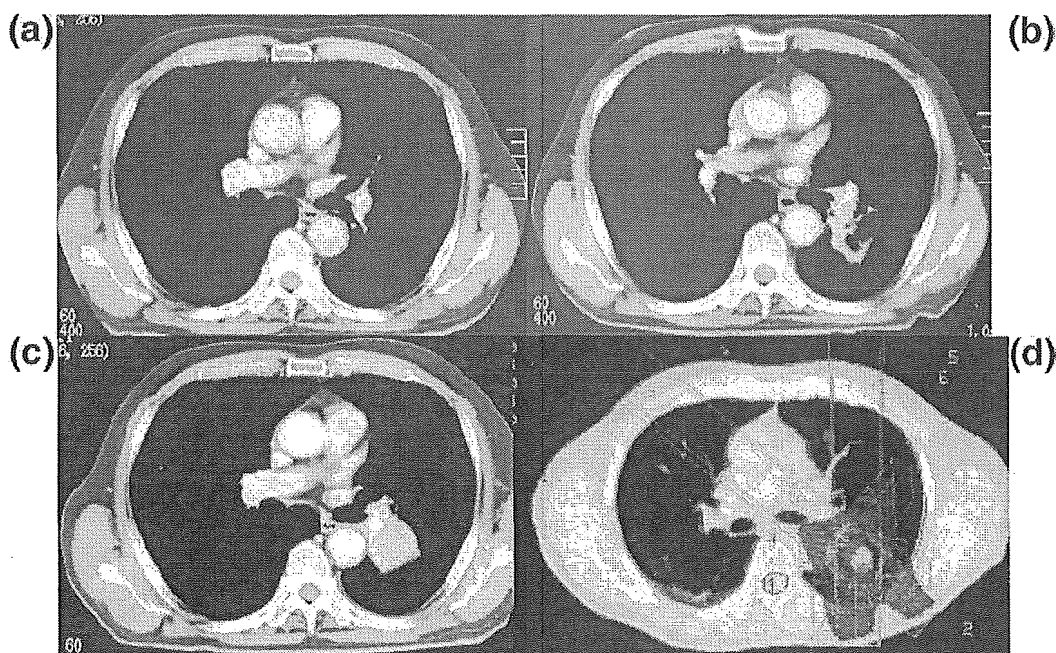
A case of T1N0M0 lung cancer showing recurrence after stereotactic radiotherapy (SRT). The computed tomography images at 7 months (b, upper right) after SRT demonstrated a new soft-tissue density as well as radiation-induced lung damage (RILD) in the marginal area of the SRT that could not be observed at 2 months (a, upper left) after SRT. Initially, the density was considered to be RILD. However, the density increased in size at 16 months (c, lower left). The tumor was finally diagnosed as a local failure from either marginal failure or regional lymph nodal failure. The dose distributions are also shown (d, lower right).
